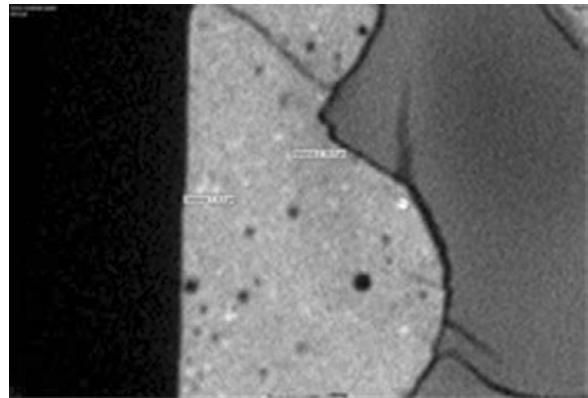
Bioactive material Biodentine in contact with dentin 1: 0.023 (X-ray microtomography v | tome | x m General Electric-Measurement & Control Solutions, Germany).
